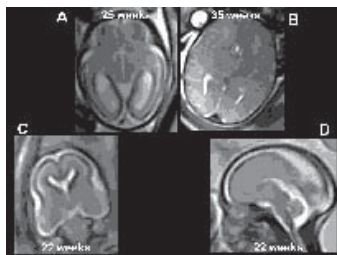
A&B, Normal MRI appearance of atria in 25 and 35 week fetus. The ventricles, generally, appear large as compared to the cerebral mantle due to incomplete development. The atria in the later pregnancy gradual reduction in size and appear very small near term. Figure 1 C&D: Normal appearance of the corpus callosum in 22 week fetus. Coronal section shows integrity of the normal midline anatomy. Sagittal section shows corpus callosum as a subtle hypointensity in the midline.
